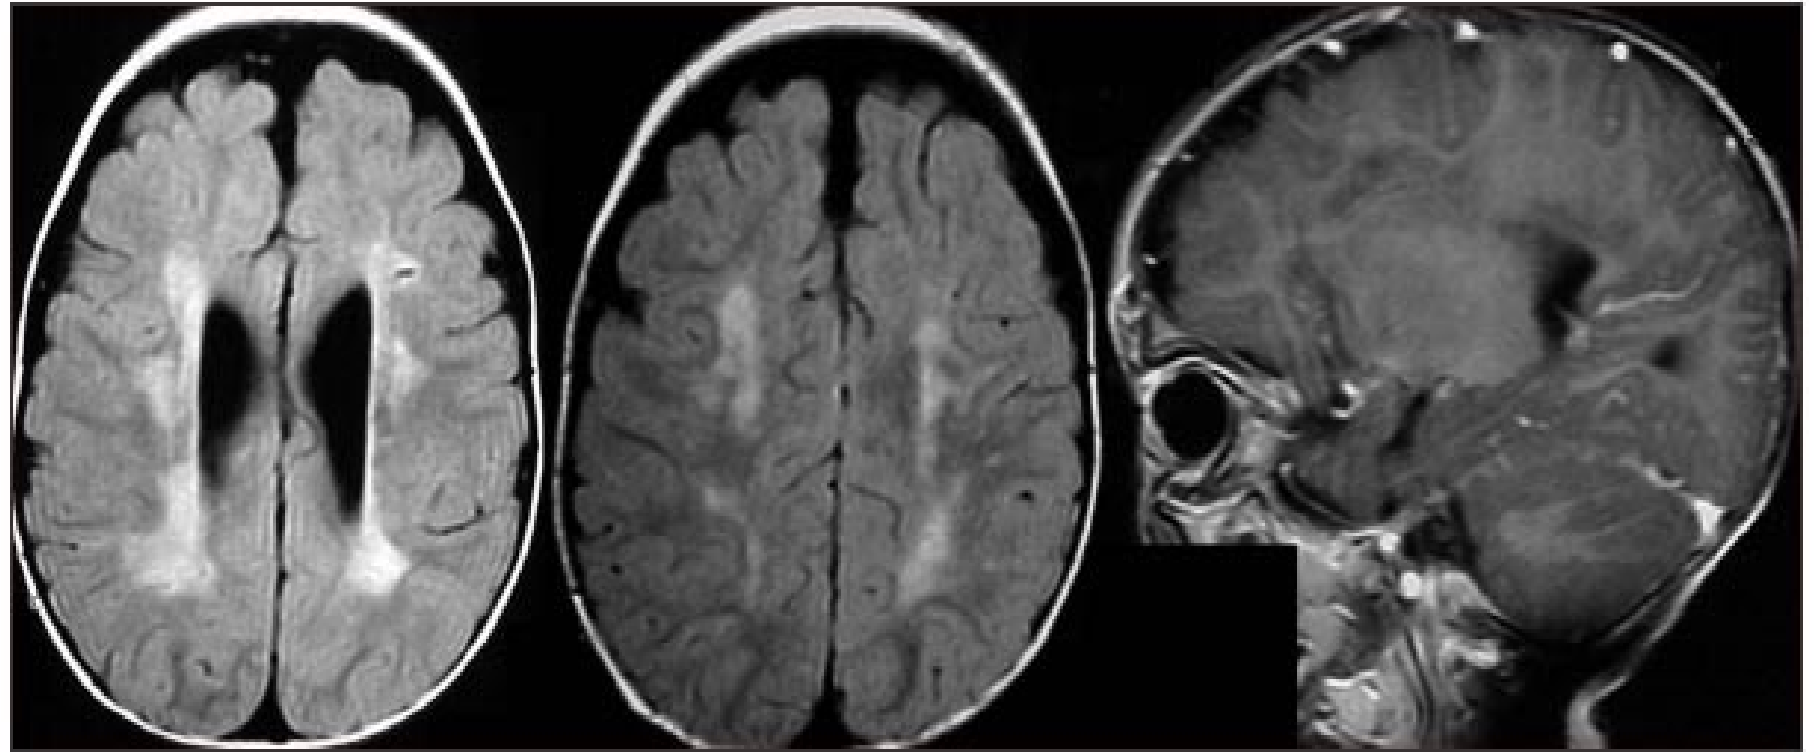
MRI examination at 21 months of age. Axial FLAIR (fluid-attenuated inversion recovery) and sagittal T1-weighted post gadolinium (MR contrast agent). T2 weighted images show white matter hyperintensities in the periventricular and centrum semiovale regions.
